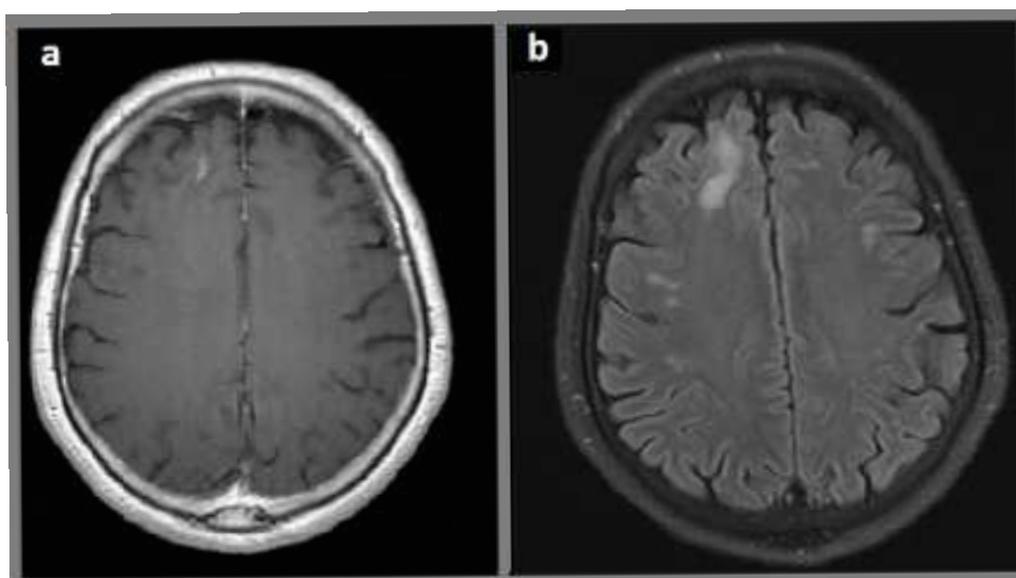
(a) DVA collector vein at contrast-enhanced T1-weighted sequence, (b) DVA associated hyperintensity at FLAIR sequence.
